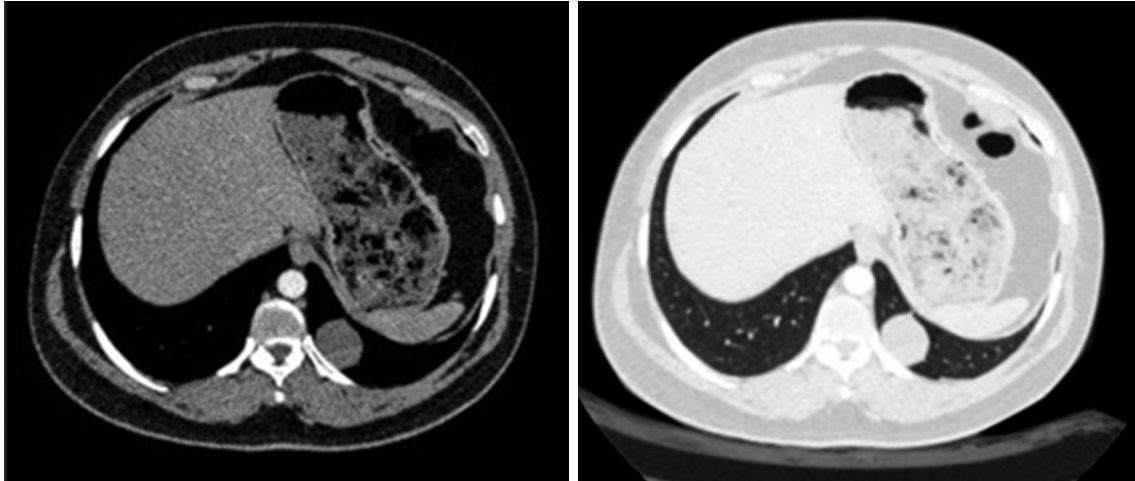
Computed tomography sections showing a supradiaphragmatic, well-circumscribed cystic lesion in the left lower lobe.
